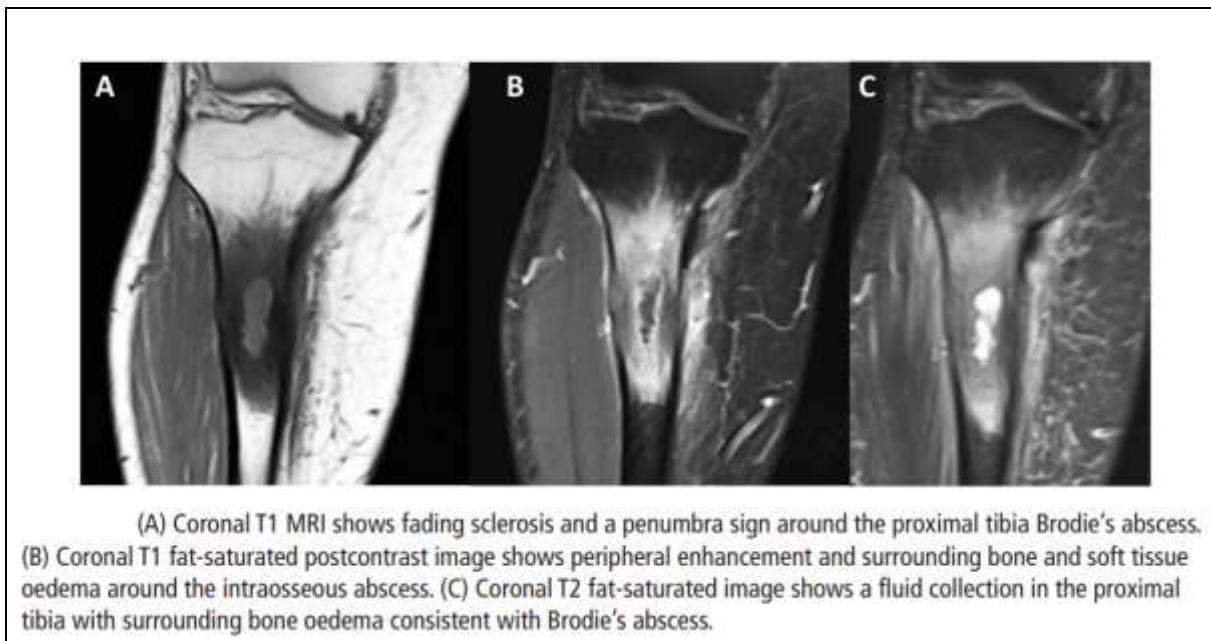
MRI of the 50-year-old patient
